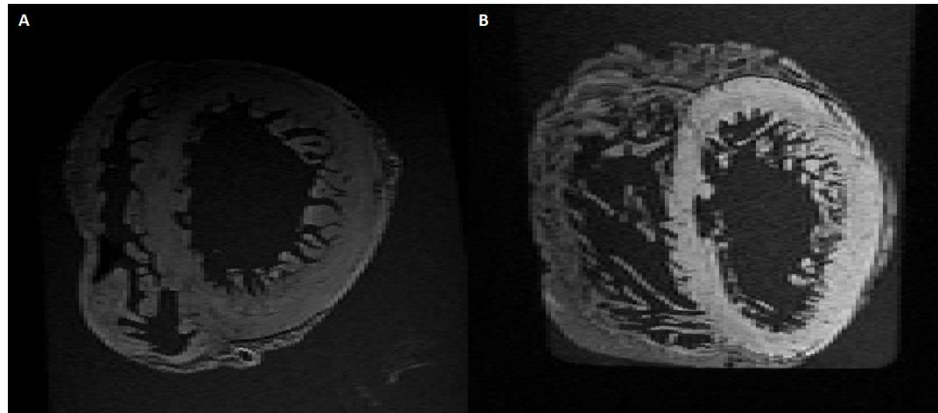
Example of (A) a suboptimal MRI scan of a heart and a (B) good MRI scan of a perfusion-fixed human heart.
